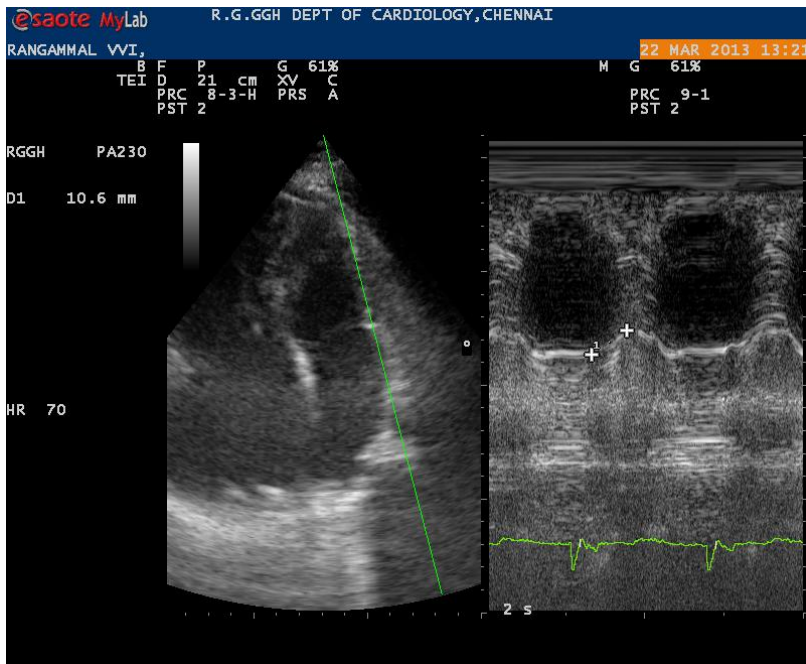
A showing Apical 4-chamber view for measuring MAPSE. The M-mode cursor placed along the lateral annulus of the mitral valve
